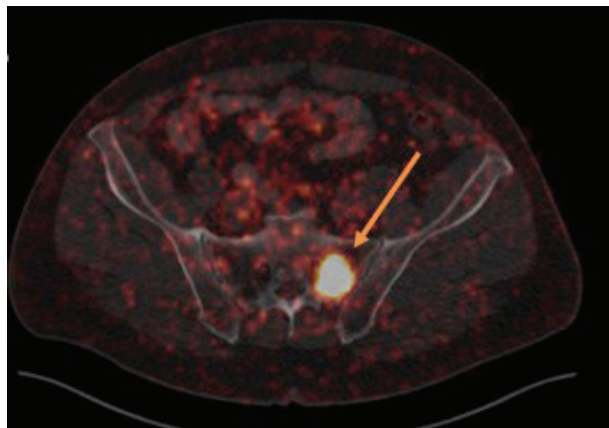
Bone metastasis in the sacrum in a patient with PSA 0.56 ng/mL. The patient had a radical prostatectomy and PSAdt of only 2 months. SUVmax 39.6.
